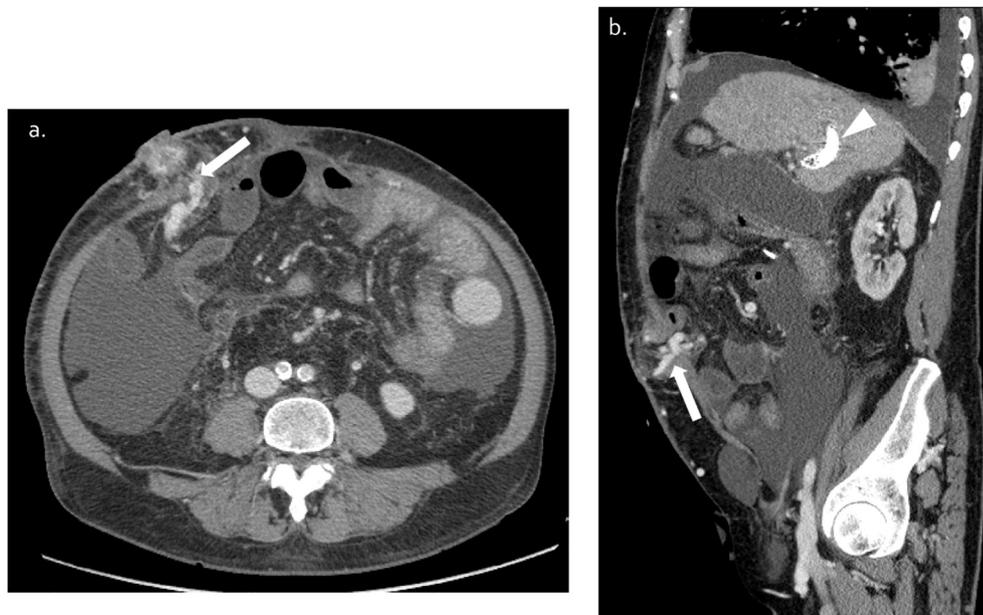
Peristomal varices: axial (a) and sagittal (b) images from a contrast enhanced CT scan demonstrate large enhancing varices (arrow) adjacent to the stoma. Note the ascites and TIPS stent (arrowhead) in this patient with cirrhosis and portal hypertension.
